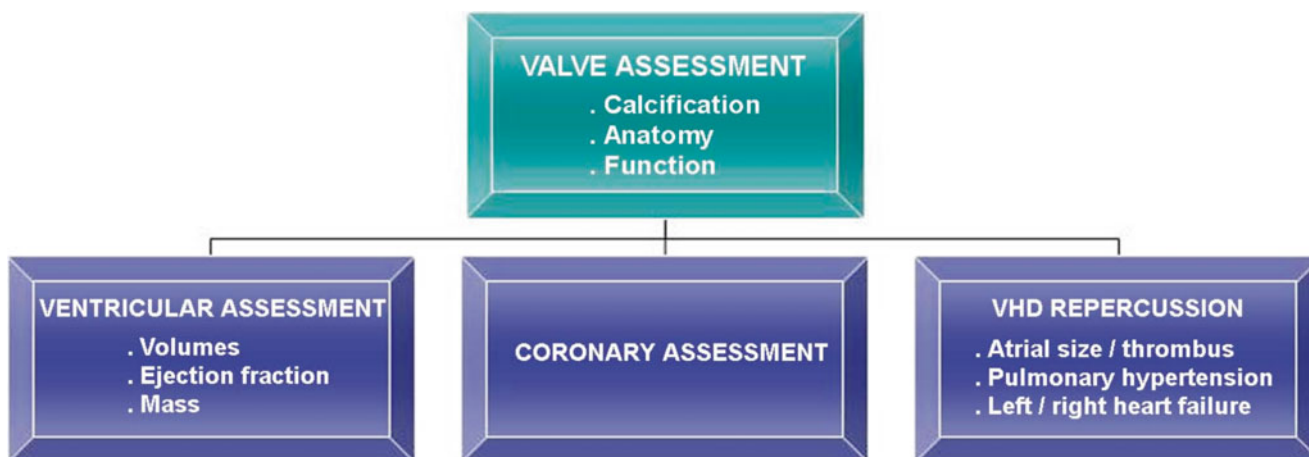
Comprehensive evaluation of valvular heart disease (VHD) with CT
